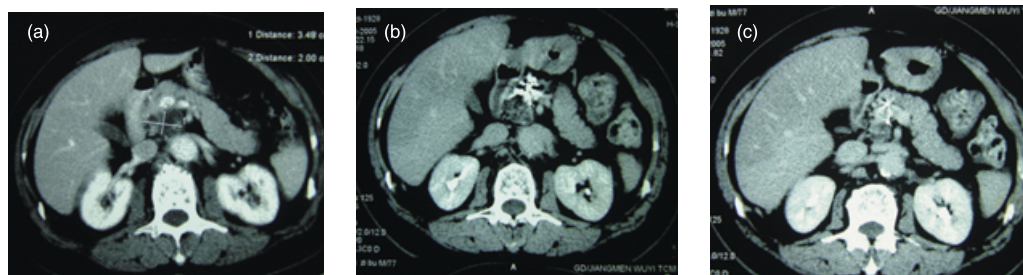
Pancreatic computed tomography scan in patient 1 (a) before treatment, (b) three months after treatment and (c) 12 months after treatment.
